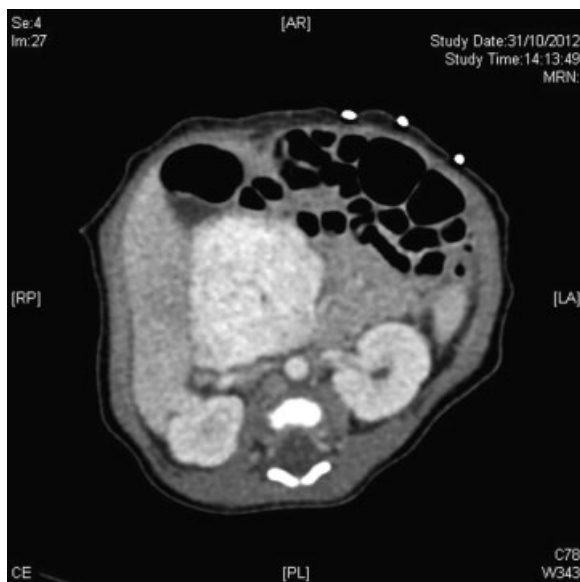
Computed tomographic abdomen showing hypervascular mass.
